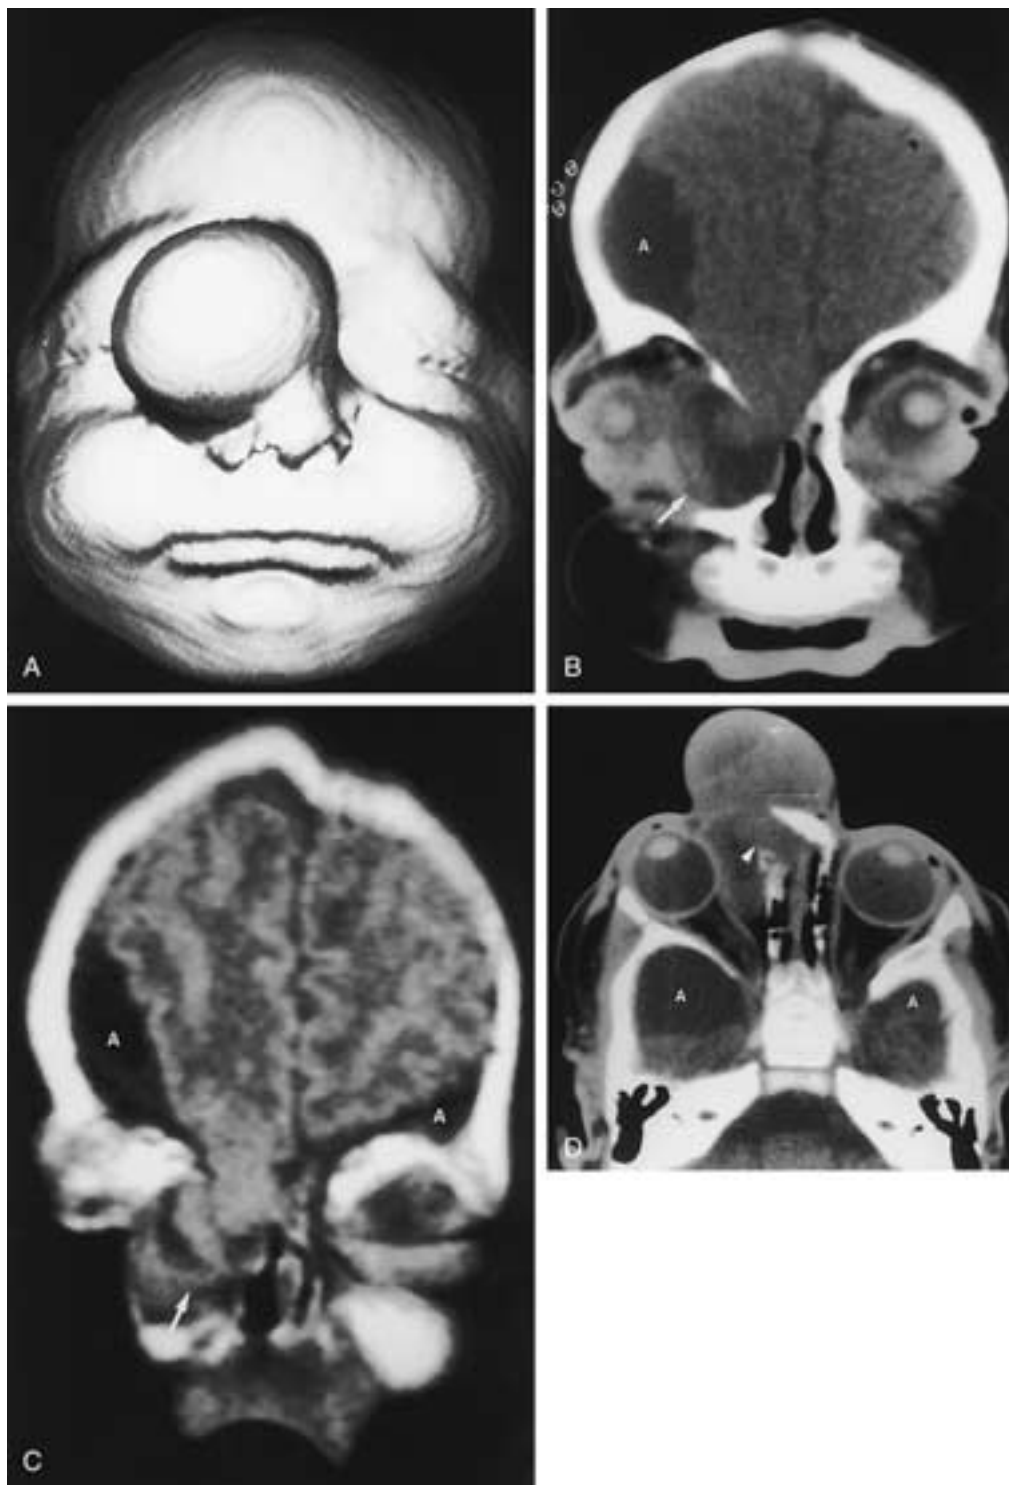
Unilateral naso-orbital cephalocele. A, Three-dimensional CT of the skin surface shows a large, eccentric, skin-covered mass at the medial right canthus. The cartilaginous nose is deviated inferiorly and leftward. Coronal CT (B) and coronal T1-weighted MR image (C) show lateral deviation of the right globe and muscle cone by inferior protrusion of a unilateral cephalocele (*white arrows*) containing brain and meninges. The cephalocele displaces the nasal mucosa medially and the orbital contents laterally. Bilateral anterior temporal fossa CSF spaces suggest concurrent arachnoid cysts (*A*). D, Axial CT demonstrates the defect (*arrowhead*) in the medial wall of the right orbit, the characteristic displacement of the muscle cone, and the narrowing of the ipsilateral nasal passage.
